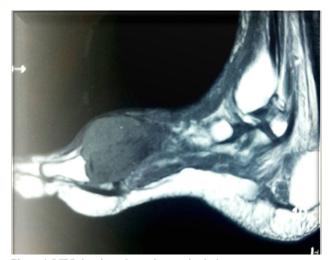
MRI showing a large destructive lesion
